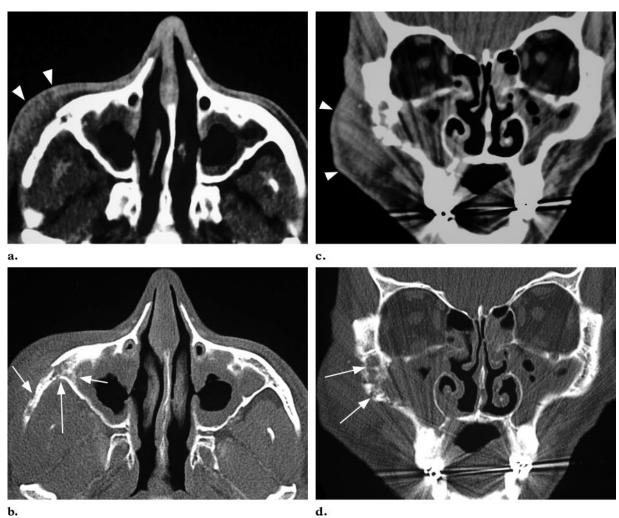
Chronic invasive fungal sinusitis due to zygomycosis in a 44-year-old man. Axial (a, b) and coronal (c, d) unenhanced CT scans show bilateral mucosal thickening in the maxillary sinuses. Bone invasion is noted in the form of mottled areas of low attenuation in the zygomatic process of the right maxillary bone; this finding is best visualized on the images obtained with bone windows (arrows in b and d). There is also invasion into the soft tissues of the right cheek (arrowheads in a and c).
